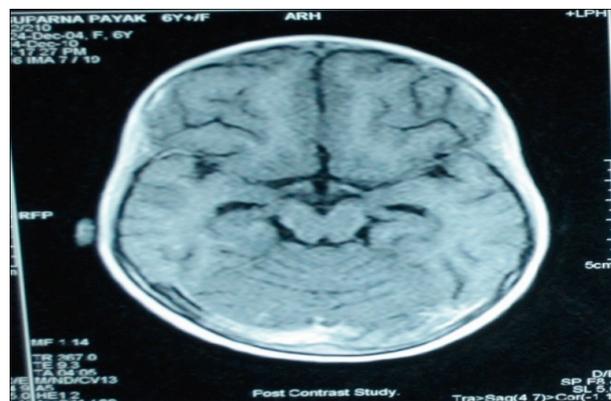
MRI showing diffuse brain shrinkage
